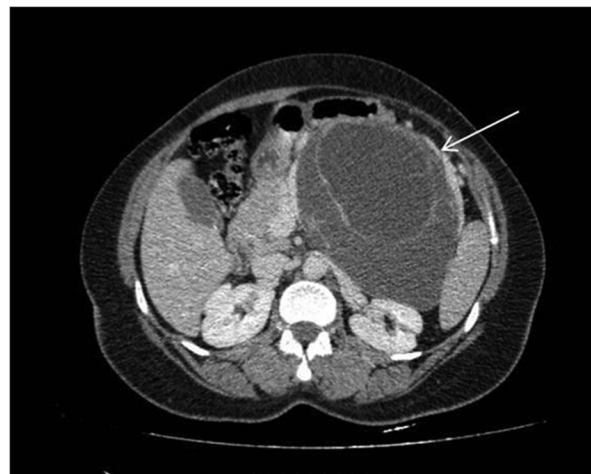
Axial contrast-enhanced computed tomography image showing a large well-encapsulated predominantly cystic multiloculated tumour arising from body and tail of the pancreas (white arrow)
